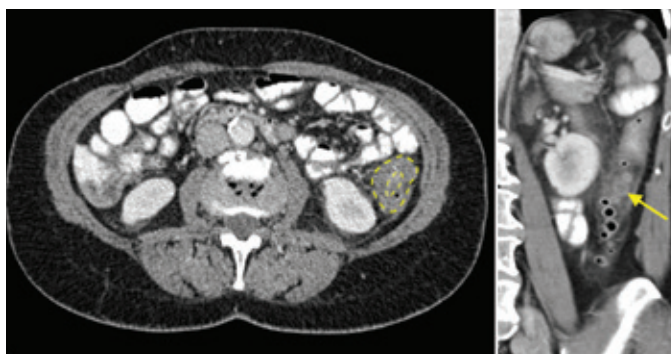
Axial CT image with coronal reformatted image showing acute diverticulitis of the sigmoid colon.
